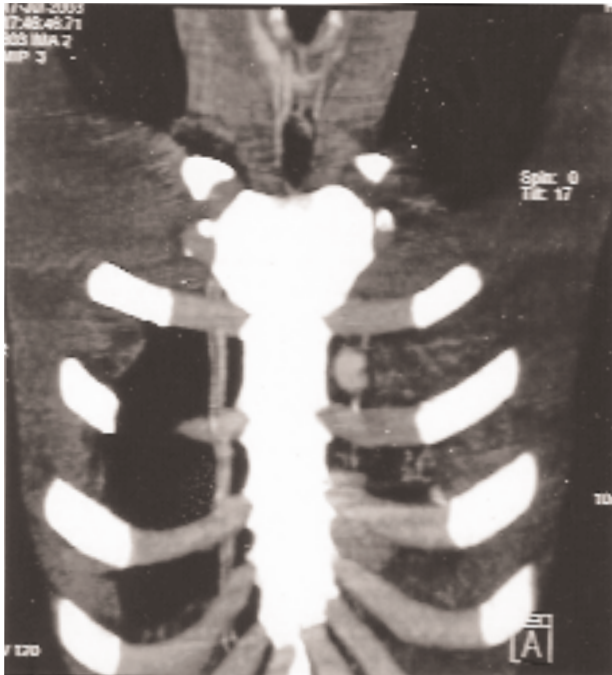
CT scan of the chest showing left hemothorax.
